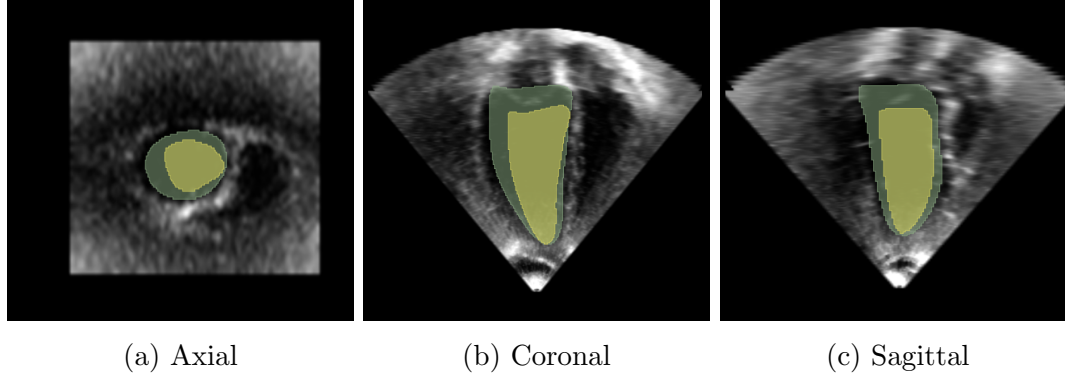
Sample apical echocardiography image with the corresponding ED and ES annotations in different planes. ED is rendered in green and ES is rendered in yellow.
